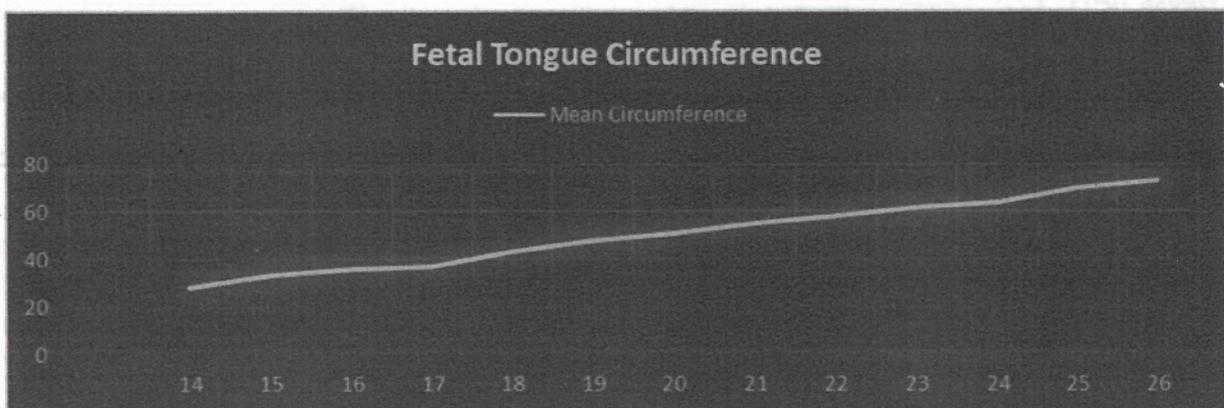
Foetal tongue circumference variation with time. X axis is gestational age (in weeks) and Y axis is mean circumference (mm). Measurements are based upon multiple (2-10) separate ultrasound measurements
